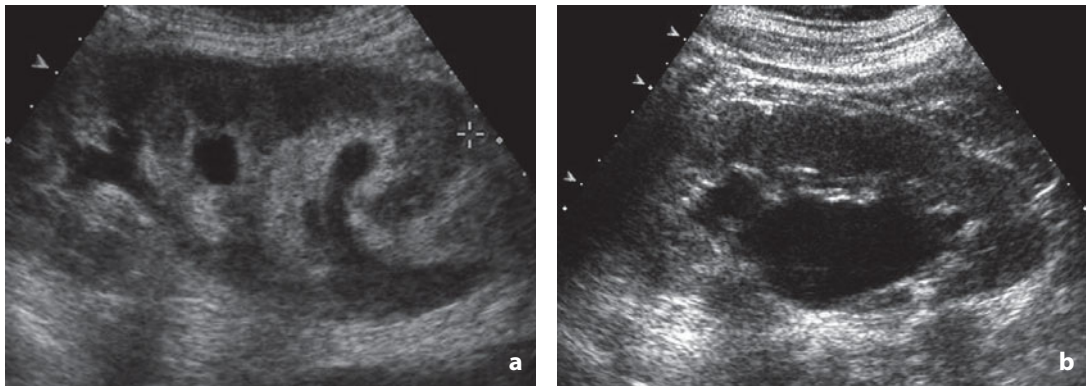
Ultrasonography. Ureteric tumor. In these two patients the ureteric tumor is manifest with secondary signs of pelvicaliceal hypotony (a) and hydronephrosis (b)
